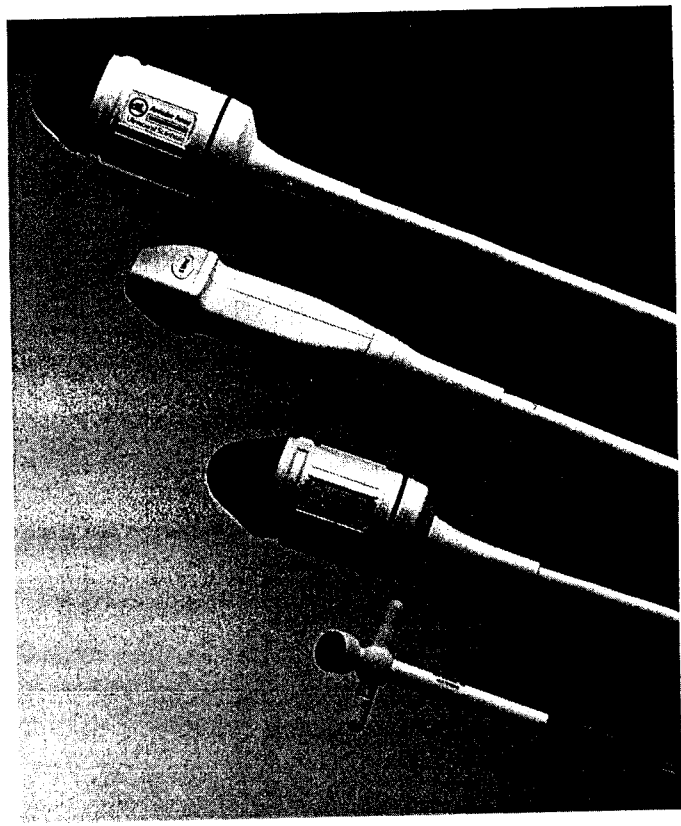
Different types of ultrasonic transducers range in frequency from 12 MHz for ophthalmic devices to 4 MHz for transducers equipped with a spinning head. (Photo courtesy of A.T.L.)
